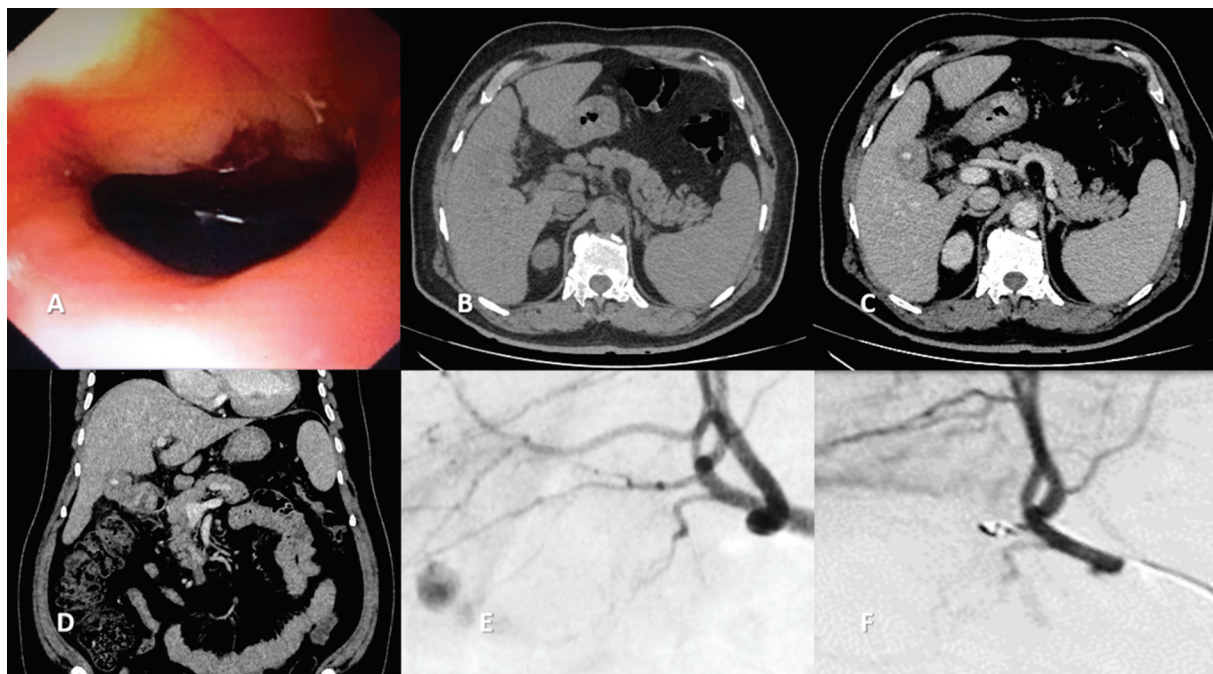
A 74-year-old male patient with hematemesis and unstable vitals. (A) Upper gastrointestinal (GI) endoscopy reveals an ulcerative submucosal tumor-like lesion with active oozing of blood in the second part of the duodenum. (B–D) Contrast-enhanced computed tomography of the abdomen. The gallbladder is contracted with abutment and loss of fat plain with the duodenum. (C, D) Postcontrast images show a contrast-filled outpouching in the gallbladder arising from its wall likely to be cystic artery pseudoaneurysm. (E) Hepatic artery angiogram shows a pseudoaneurysm arising from the cystic artery. (F) Postembolization status of the cystic artery using the front door technique.
